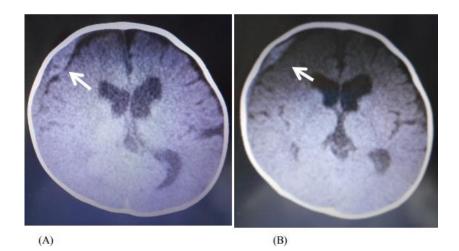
In the follow-up CT scans, we can see that the dense area of bleeding under the skull got bigger on Day 3 (pointed by the arrow), and then it got smaller again on Day 4 (also pointed by the arrow). We have two images: one from Day 3 (A) and one from Day 4 (B).
